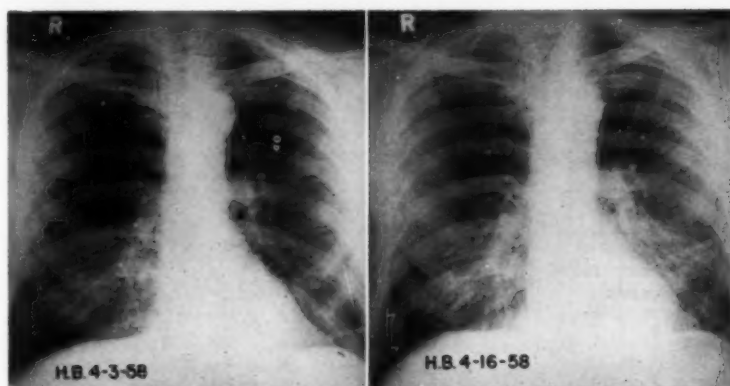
Roentgenograms of Case 1. That on the left was made preoperatively. The film on the right was obtained during the acute fatal illness on the eighth post-operative day.
